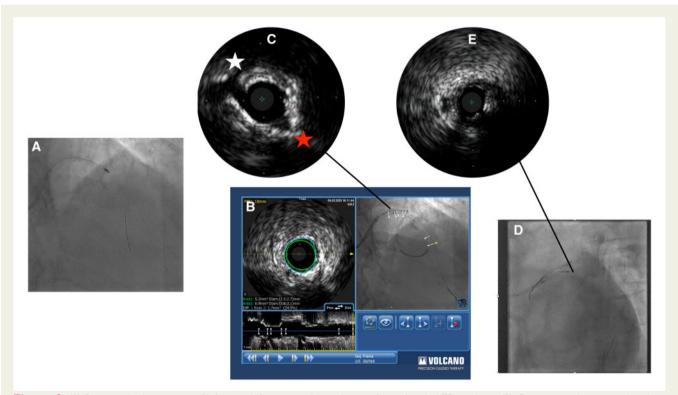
(A) Rotational atherectomy of left main–left anterior descending performed with 1.75 mm burr. (B) Co-registered intravascular ultrasound of left anterior descending–left main demonstrating distal landing zone in left anterior descending. (C) Intravascular ultrasound of left anterior descending ostium, wire seen in left circumflex (white star) disruption of calcium (red star) following rotational atherectomy. (D and E) Intravascular ultrasound of left circumflex demonstrating severe proximal disease.
